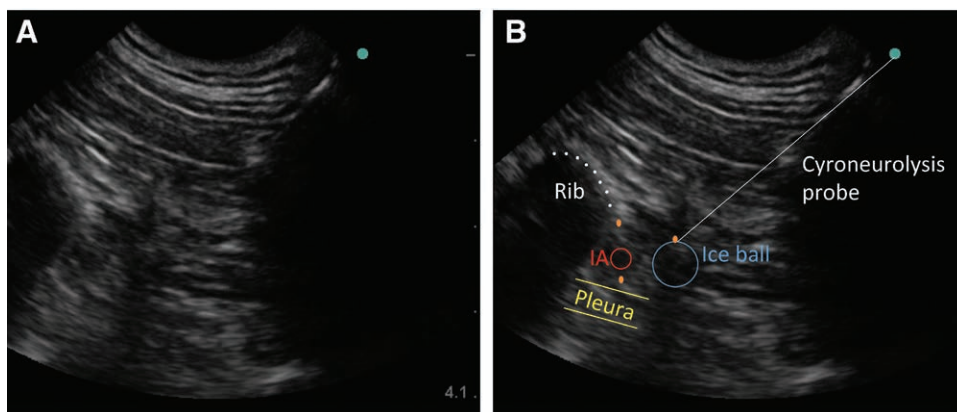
A, A parasagittal ultrasound view of T11 intercostal nerve where cryoneurolysis was performed. B, Same image in A, but with labels. Blue circle indicates area of ice ball created from cryoneurolysis; cyan dot, caudal to the nerve; IA, intercostal artery; orange dots, 3 dots indicating where cryoneurolysis freeze-warm cycles performed relative to intercostal nerve; white line, trajectory of cryoneurolysis probe.
